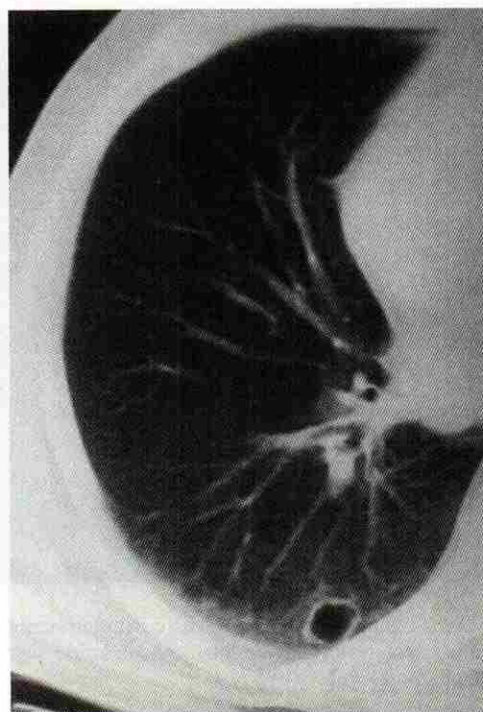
Computed tomogram of colon cancer metastatic to the lung. Note irregular but relatively thin-walled cystic structure. This is an unusual manifestation of adenocarcinoma metastatic to the lung.
